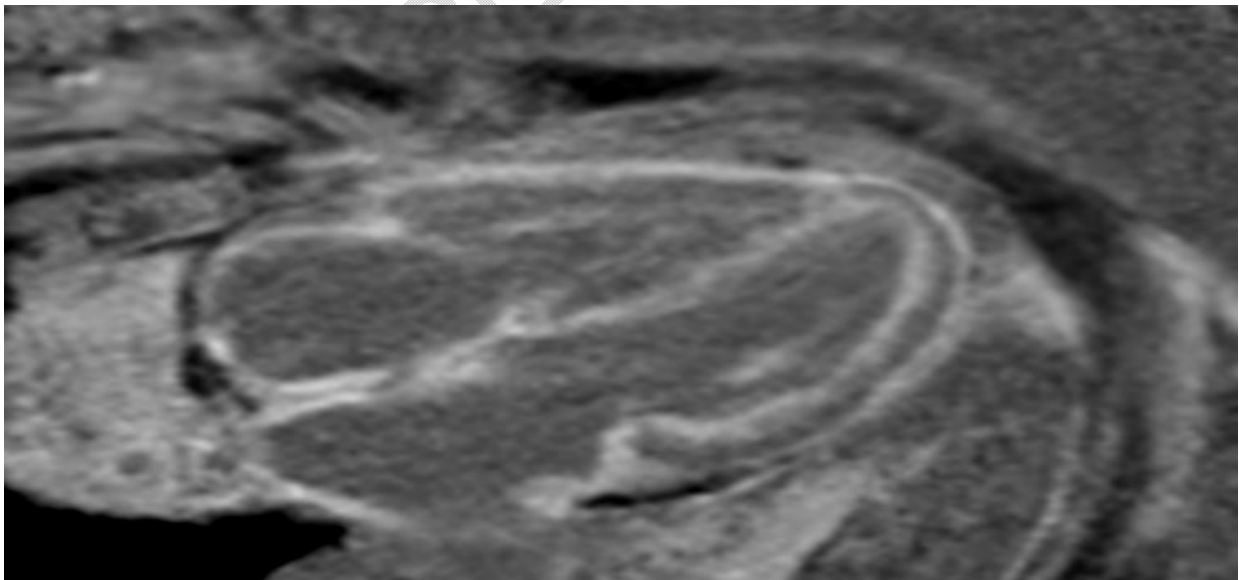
Cardiac MRI, late diffuse subendocardial enhancement
